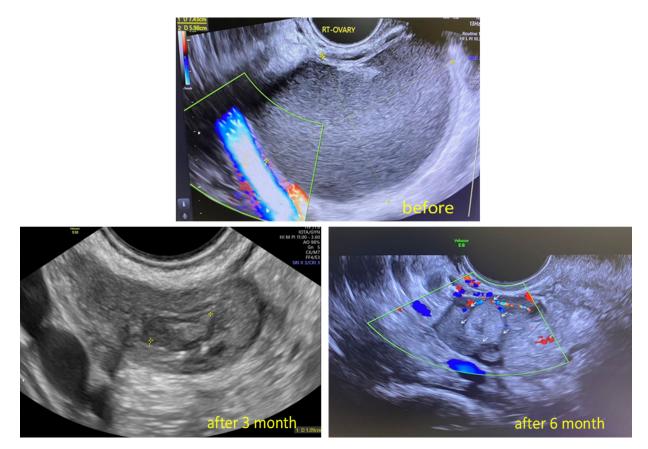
Ultrasound images before sclerotherapy and after sclerotherapy. A considerable reduction in the size of the ovarian endometrioma can be observed (from 8 to 1 cm).
